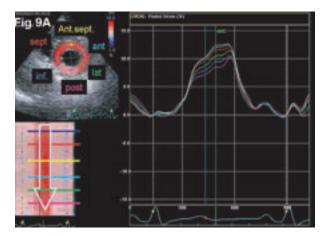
A. Normal individual. Left: Color-coded two-dimensional speckletracking echocardiographic radial strain in a normal individual. Top left: homogeneous color coding during systole without segments of delayed contraction (6 segments-clockwise: Ant. sept = anteroseptal; ant = anterior; lat = lateral; post= posterior; inf = inferior; sept = septal.Bottom left: color-coded map representing strain as relative wall thickening of individual segments in red colors of different brightness related to the cycle time period and demonstrating peak strain in end-systole without delay between each of the segments; arrow = peak strain, segments by colored lines. represented Corresponding radial strain curves are lined up during the cycle indicating no evidence of dyssynchrony. B. Dilated cardiomyopathy. Left: Color-coded speckle tracking echocardiography representing delayed contraction posteriorly. Right: Corresponding segmental radial strain curves. The time delay between the ventricular septum (red curves) and the lateral wall (green curve) is 340 msec, representing distinct dyssynchrony. AVC = aortic valve closure(Reproduced from Nesser HJ, Winter S: Speckle tracking in the evaluation of left ventricular dyssynchrony. Echocardiography 2009;26;324-336).¹⁸
